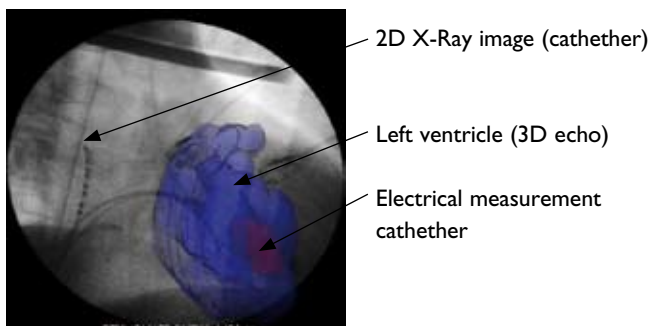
Data fusion of X-ray and ultrasound.
